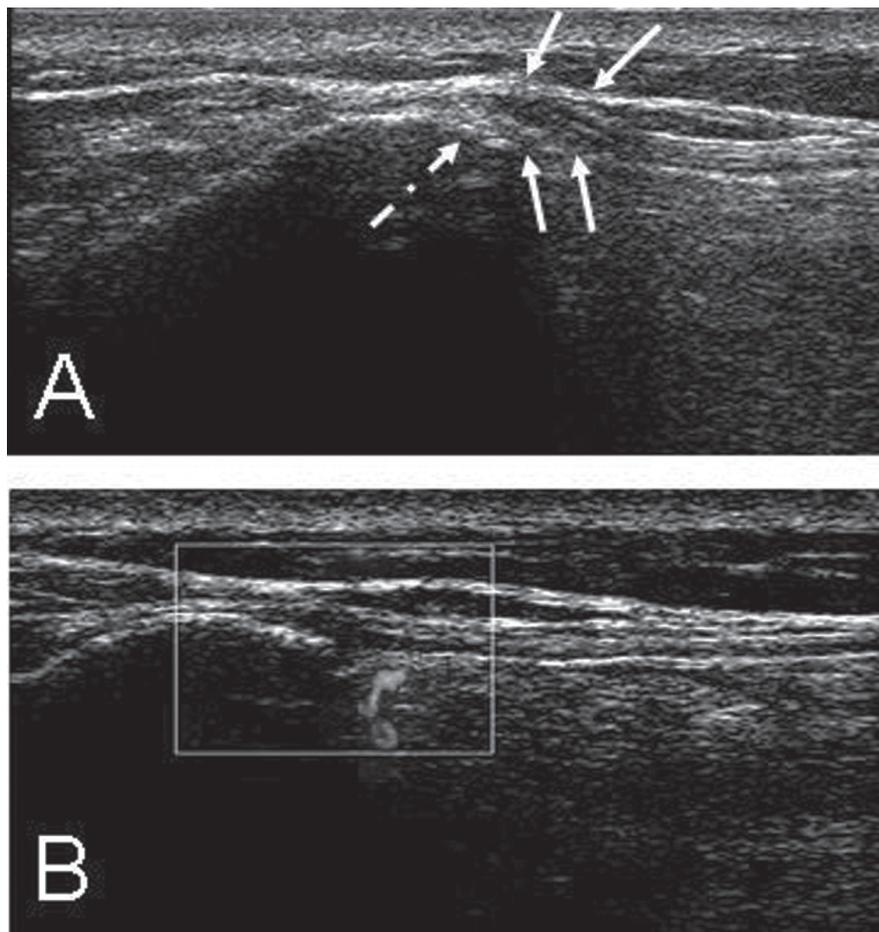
B-mode ultrasound of the left posterior superior iliac spine (PSIS).
